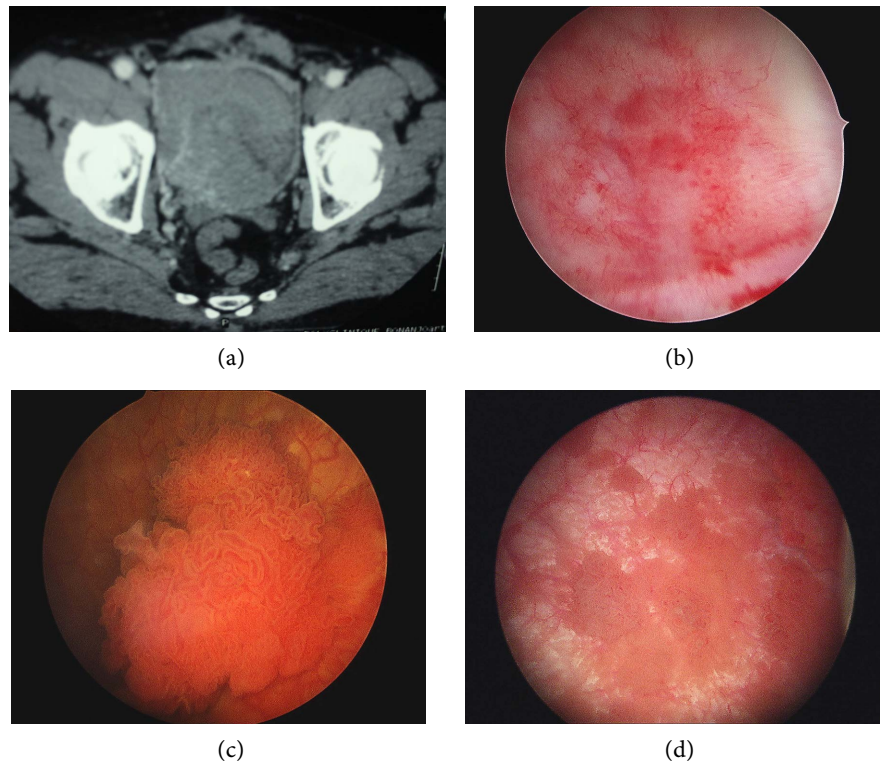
Imaging of bladder tumors. (a): computed tomography image of bladder tumor; (b): Endoscopic view of carcinoma-in-situ ($\times 50$ magnification); (c): Endoscopic view of a pedunculated tumor ($\times 50$ magnification); (d): Endoscopic view of a sessile tumor ($\times 50$ magnification).
